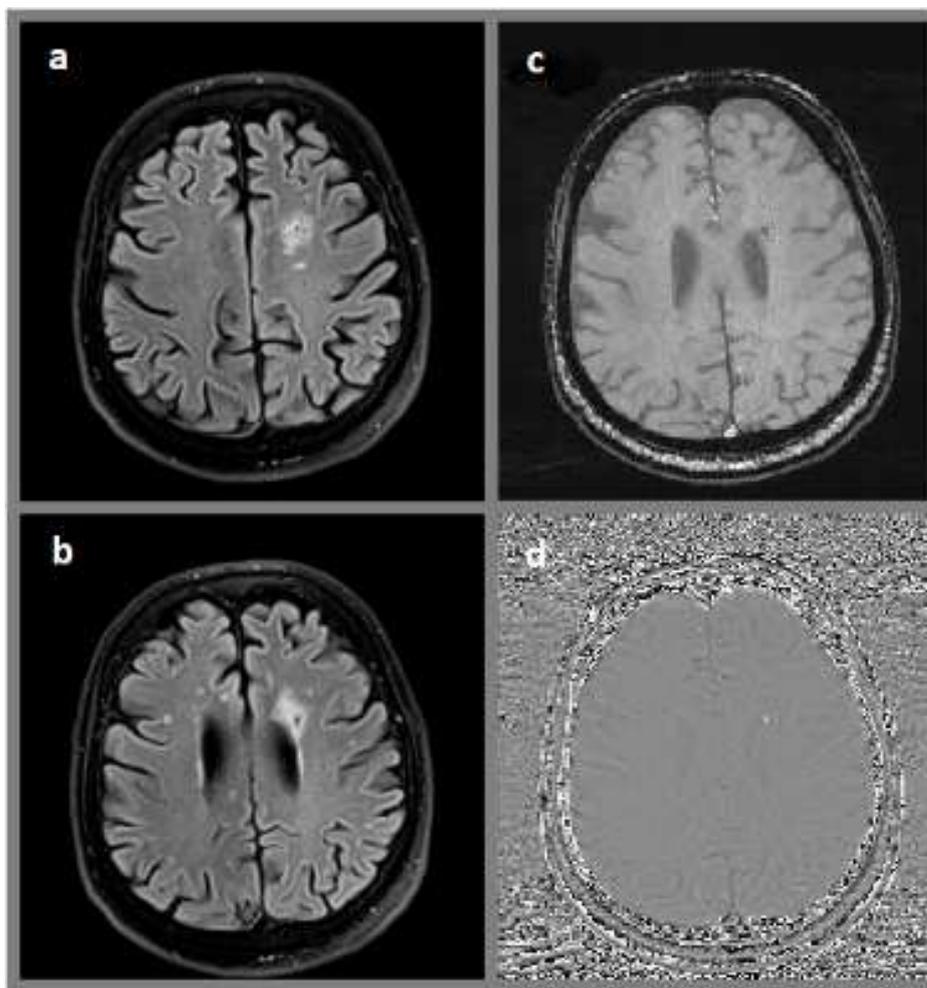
(a, b) DVA associated hyperintensity at FLAIR sequence, (c, d) DVA collector vein at SWI and phase images.
